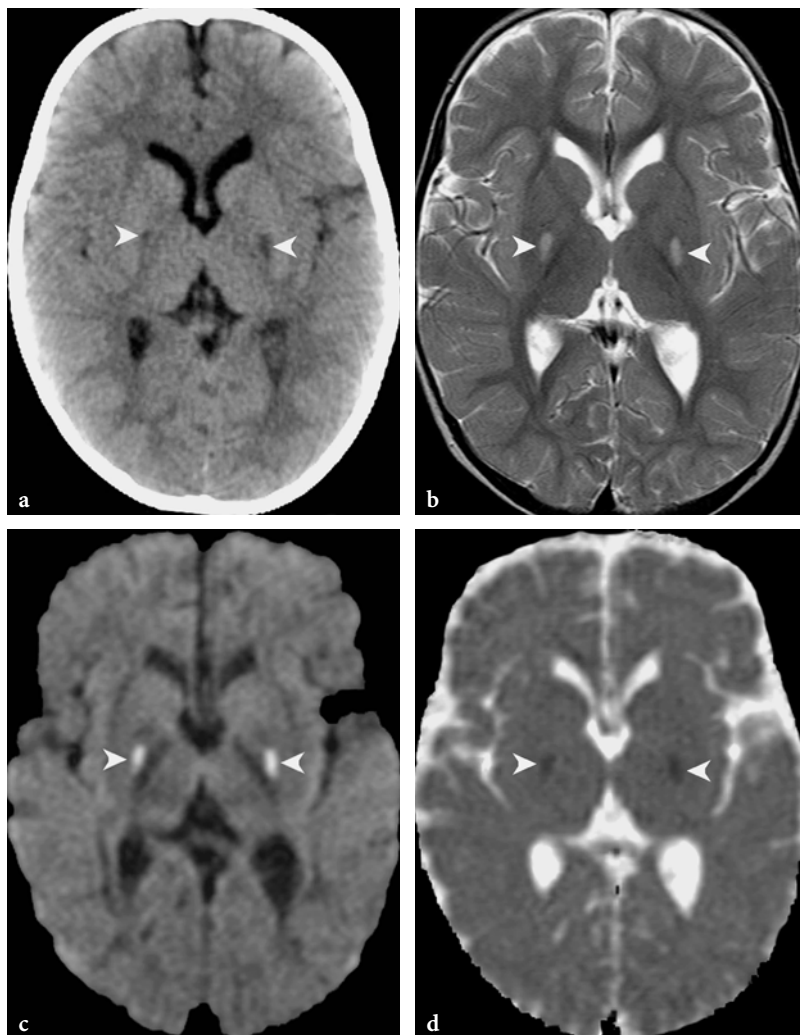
Imaging findings in a 3-year-old female patient with methylmalonic acidemia (during the first acute metabolic decompensation). a Axial CT image of the brain, showing bilateral hypodensities within the globi pallidi (arrowheads). b Axial T2-weighted fast spin-echo image 2 days after the CT examination. Within the posterolateral parts of the globi pallidi bilateral symmetrical hyperintensities are seen (arrowheads). The rest of the basal ganglia are spared. c Axial diffusion-weighted echo planar image ($b=1000s$). The lesions within the globi pallidi are markedly hyperintense (arrowheads), suggesting cytotoxic edema. d Axial apparent diffusion coefficient (ADC) map image. The lesions are hypointense (arrowheads), confirming decreased water diffusion
